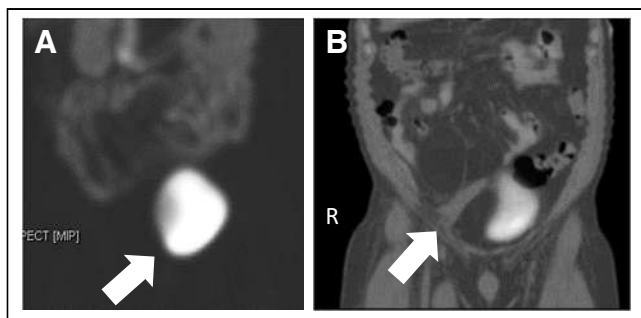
(A) SPECT image of abdomen and pelvis showing deviation of urinary bladder (maximum-intensity projection). Arrow shows deviation of urinary bladder. (B) SPECT/CT image of abdomen and pelvis showing deviation of urinary bladder by large mass (coronal view). Arrow shows deviation of urinary bladder in CT portion of image.
